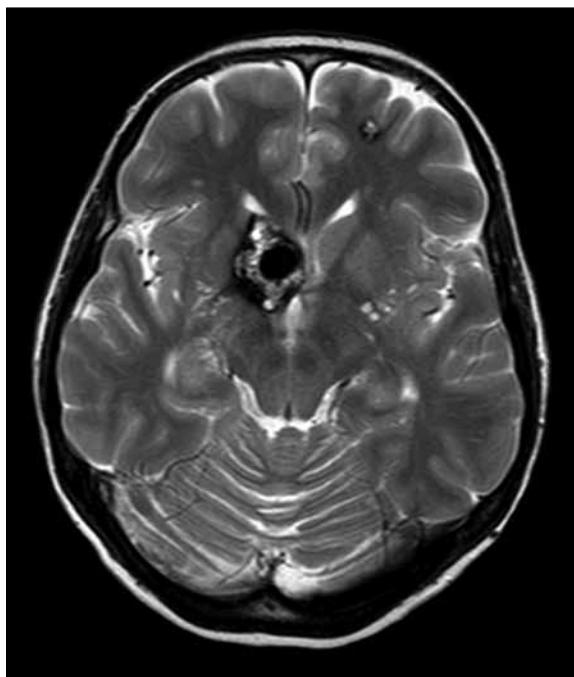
Head MRI scan, T2-weighted image, transverse plane. Non-homogenous foci of mixed signal intensity with blood, at different stages of aging, in the right brain hemisphere, adjacent to the caudate nucleus head and in the left frontal lobe.
